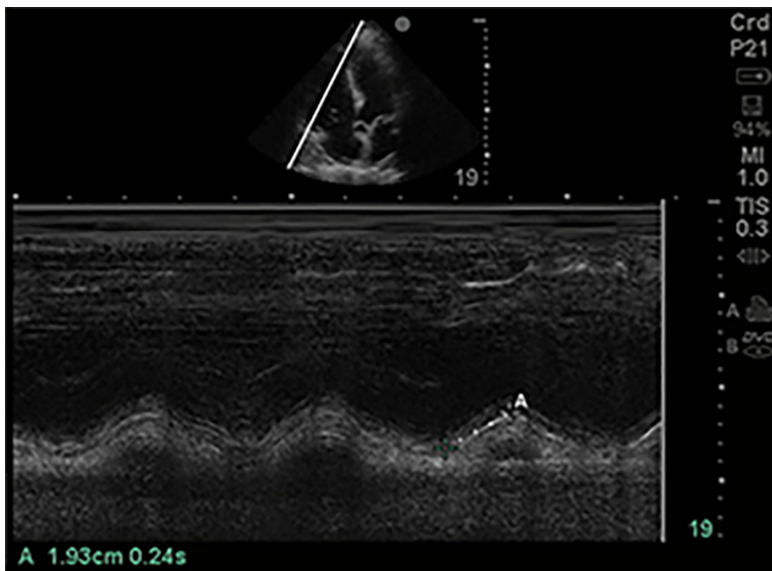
Tricuspid annular planar systolic excursion (tricuspid annular plane systolic excursion). Phased array probe (1-5 MHz) in “Cardiac” preset, placed in apical 4 chamber view. M-mode line is placed across the lateral tricuspid annulus to assess longitudinal contraction of the right ventricle (RV) free wall, a regional surrogate for RV function. The tricuspid annular planar systolic excursion of this patient was 1.93 cm which is low normal.
